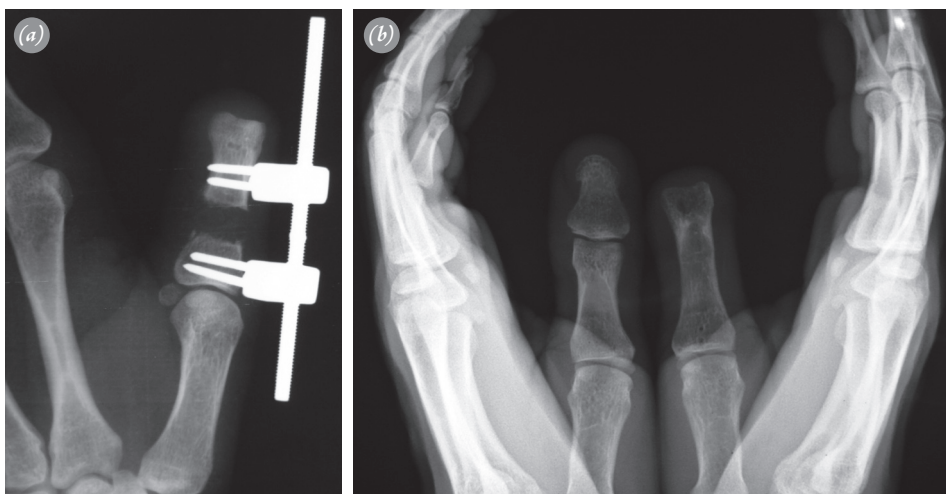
(a) Lengthening of the distal phalanx was initiated 10 days after the osteotomy; it was continued until the tip of the proximal phalanx reached the middle of the opposite distal phalanx. (b) The acquired osseous length after full consolidation of the gap, as seen in this radiograph at the final follow-up evaluation.
